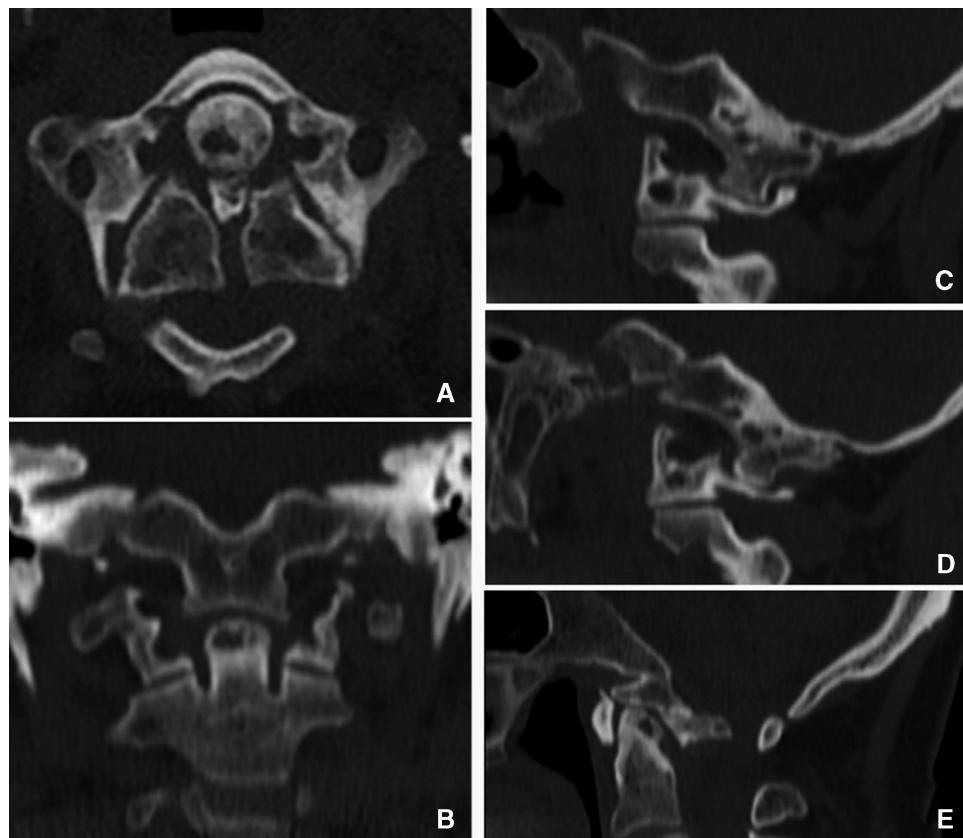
Preoperative CT-scan multiplanar reconstruction showing the spinal canal stenosis due to the posterior projection of the 3rd occipital condyle (A), the relationship between the odontoid tip and the clival condyle on the frontal (B) and sagittal (E) plane, the connection between the left (C) and right (D) proper occipital condyles and the posterior arch of the atlas.
